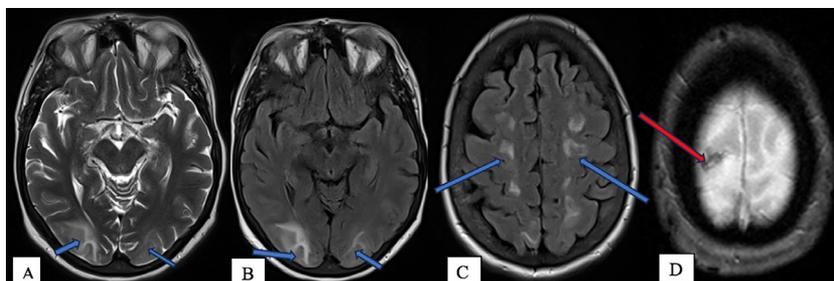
Cerebral MRI showing areas of T2 hypersignal (A) and T2 FLAIR (B, C) in the occipital and frontal regions, cortico-subcortical, with no abnormal diffusion signal or contrast, and a subarachnoid hemorrhagic lesion on the right frontal T2* (D).
